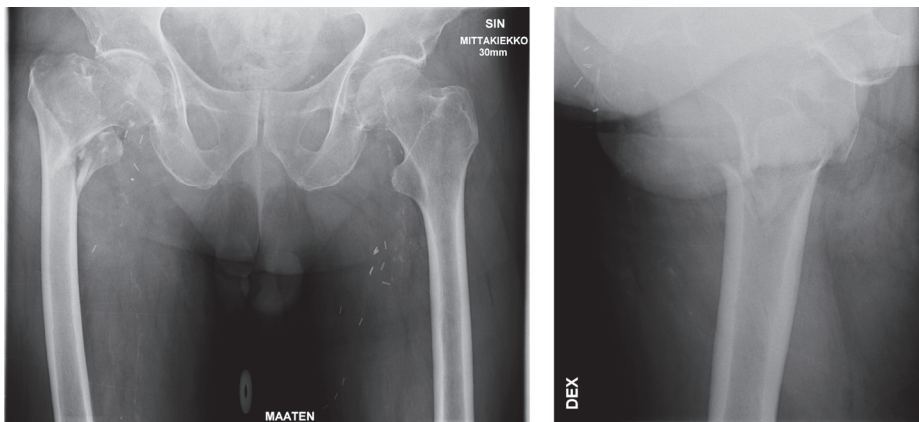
X-ray image of trochanteric fracture.
